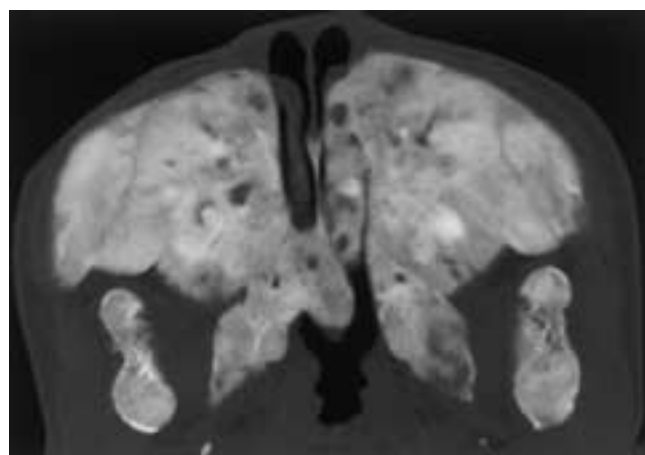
McCune-Albright syndrome in a 12-year-old boy with café au lait spots, polyostotic fibrous dysplasia, and precocious puberty. Axial CT reveals expansion with diffuse ground-glass opacification of the maxilla, pterygoid plates, mandible, and nasal turbinates. There is narrowing of the nasal cavity.
